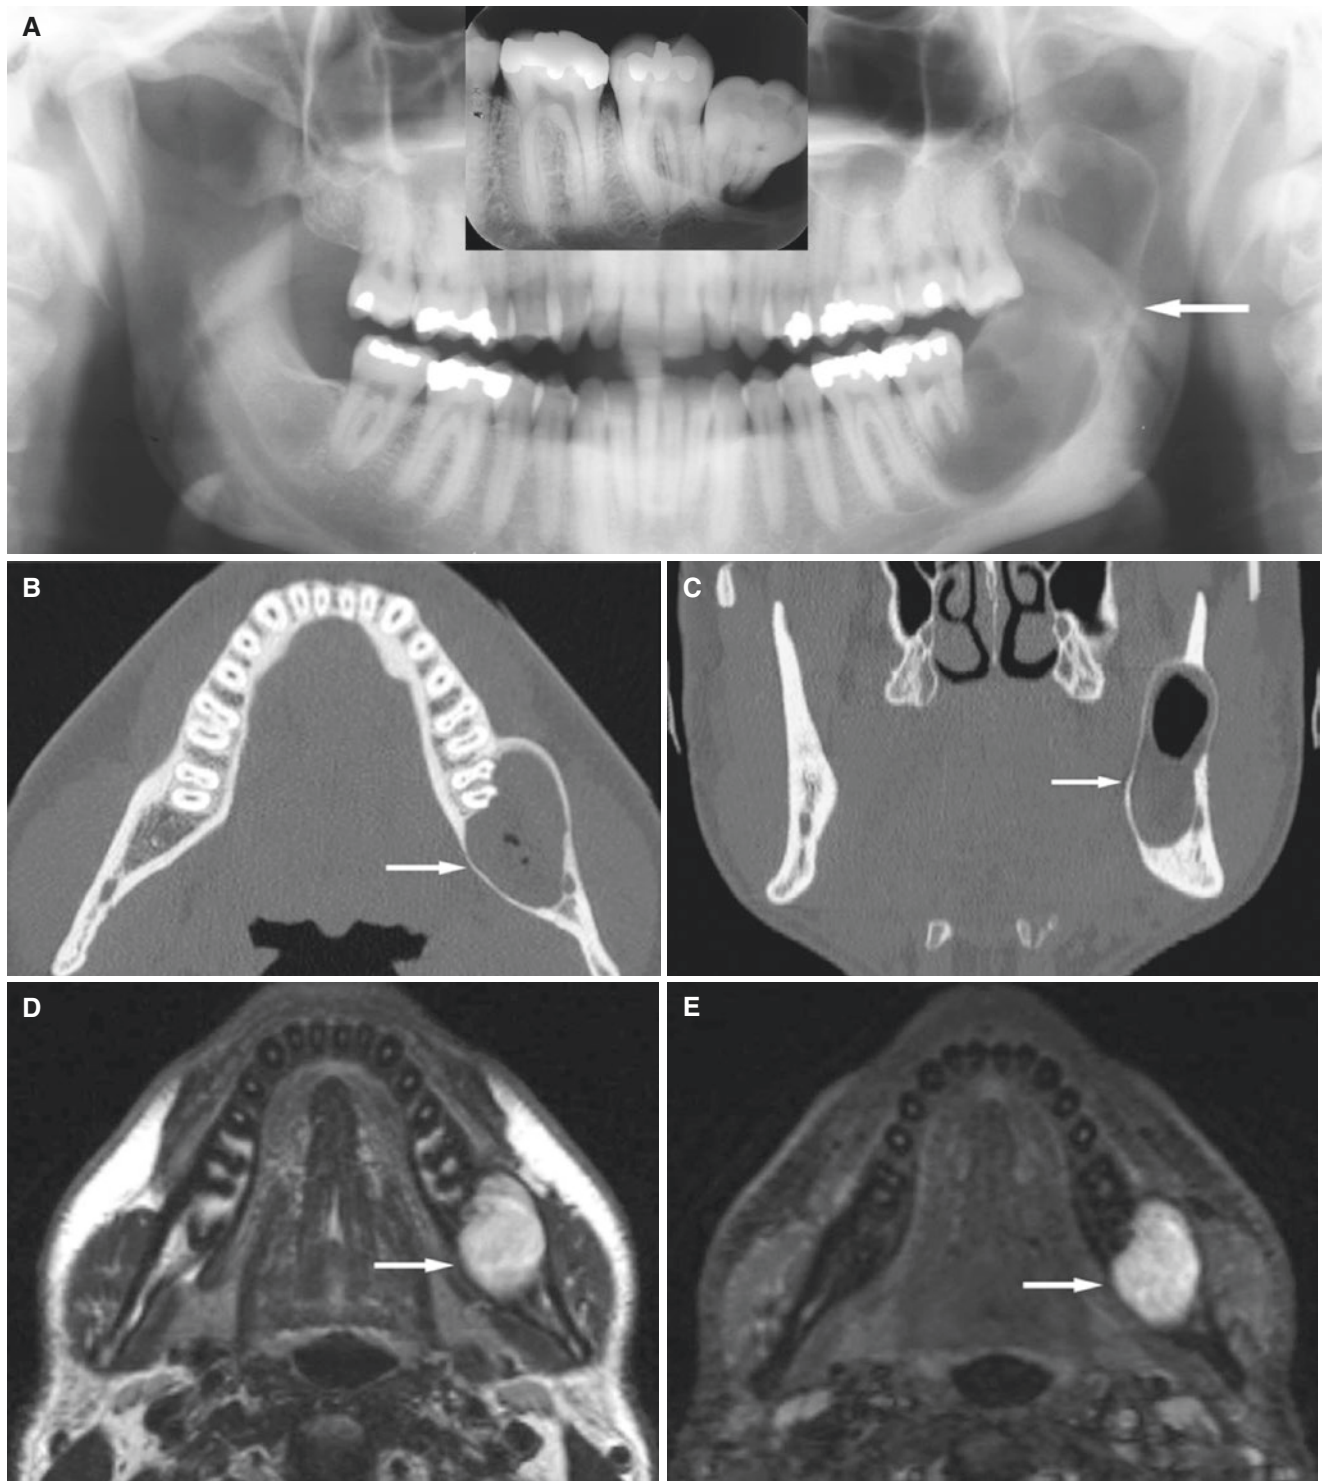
Ameloblastoma, unicystic, mandible; 33-year-old male with drainage into oral cavity as the only symptom several months after the third molar surgery. (A) Panoramic view shows unilocular radiolucency with sclerotic border (*arrow*). Note intraoral view before surgical removal of the third molar, suggesting the lesion (which was not detected by the dentist). (B) Axial CT image shows expansive process with intact, sclerotic cortical outline and with mandibular canal in periphery (*arrow*). Note root resorption. (C) Coronal CT image shows expansion of thin intact, cortical outline (*arrow*), and some air.
